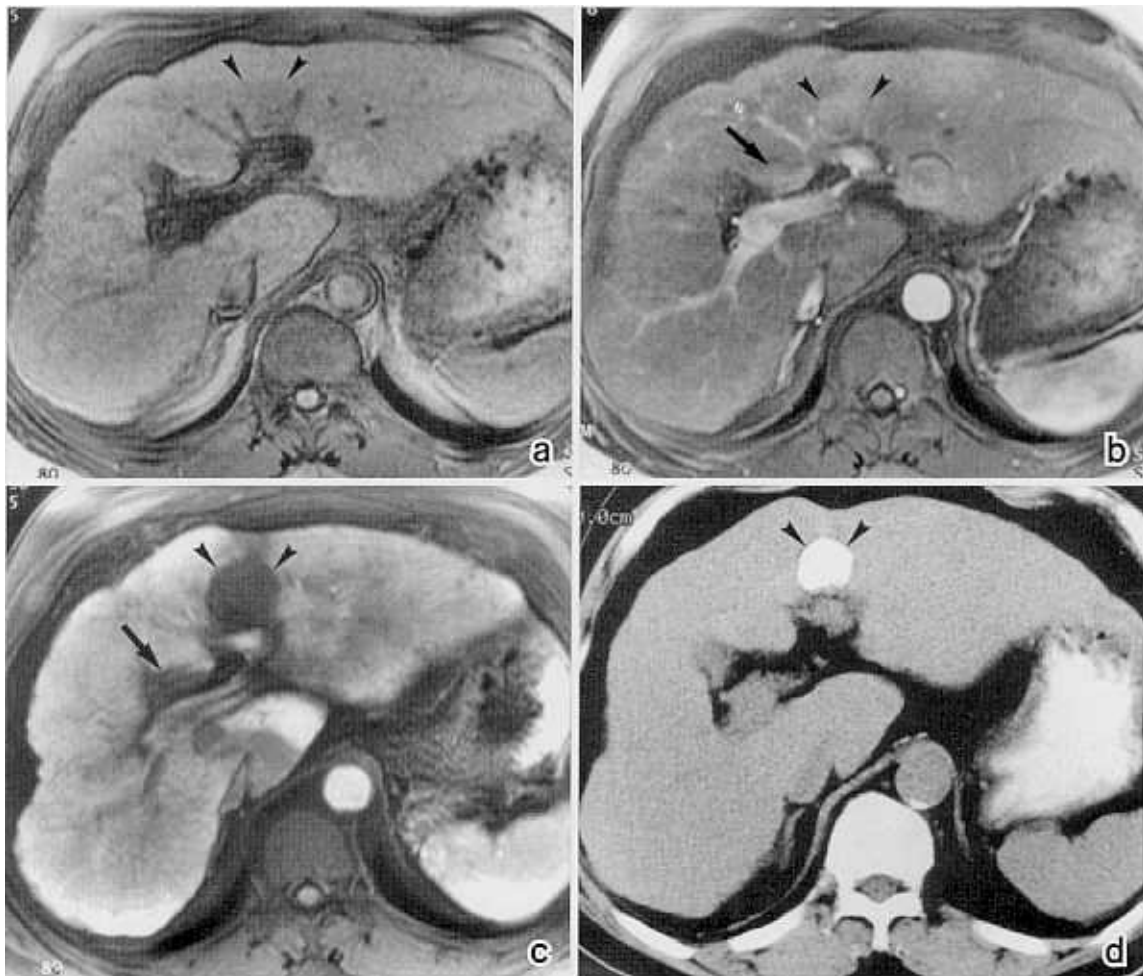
Hepatocellular carcinoma and a pseudolesion from a focal hemodynamic variation in a 59-year-old man with liver cirrhosis. (a) Unenhanced T1-weighted MR image shows a low signal intensity nodule (arrowheads) in left lobe of liver. (b) Contrast-enhanced MR image obtained during first phase (arterial dominant phase), 10 sec after intravenous administration of contrast agent was started, shows contrast enhancement of left lobe lesion (arrowheads). Another subcapsular contrast enhancement is also seen in the posterior portion of quadrate lobe (arrow). (c) MR arterial portogram obtained during first phase of imaging 20 sec after initiation of contrast material injection via splenic artery shows a nodular perfusion defect (arrowheads) which is larger than the corresponding contrast-enhanced lesion on (b). Another perfusion defect in the quadrate lobe (arrow) is also matched to the contrast enhancement on (b). (d) Iodized oil CT image obtained 55 days after transarterial chemoembolization demonstrates dense nodular uptake of iodized oil in left lobe lesion. There was no evidence of focal lesion or growing tumor on posterior portion of quadrate lobe during a 2-year follow-up period (not shown), and the abnormal perfusion was thought to be a pseudolesion from a focal hemodynamic variation.
